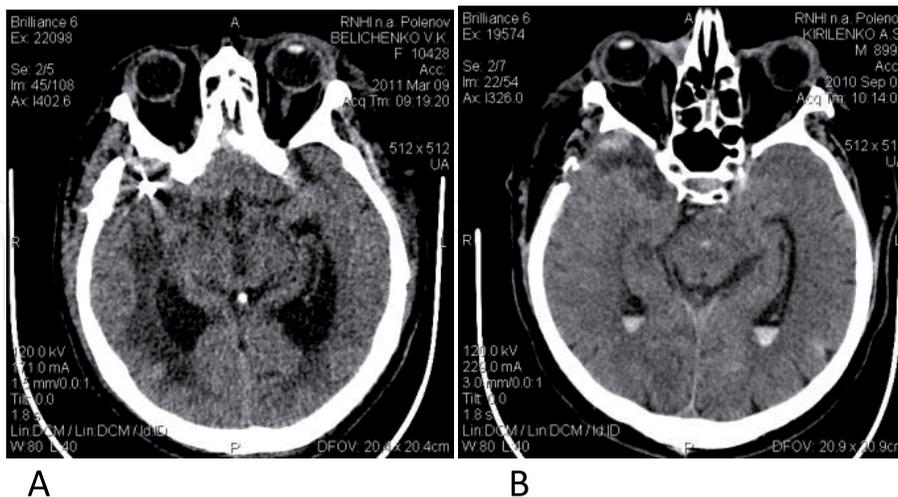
Fisher CT III-IV in patients with a cerebral aneurysm, right ACA-ACA (A), left ACA-ACA (B).
